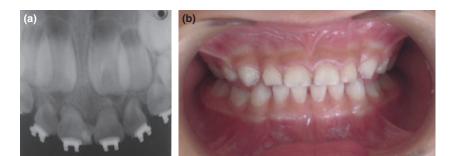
Radiograph taken 10 months after injury showing complete resorption of the apical fragments with developing permanent incisors.
